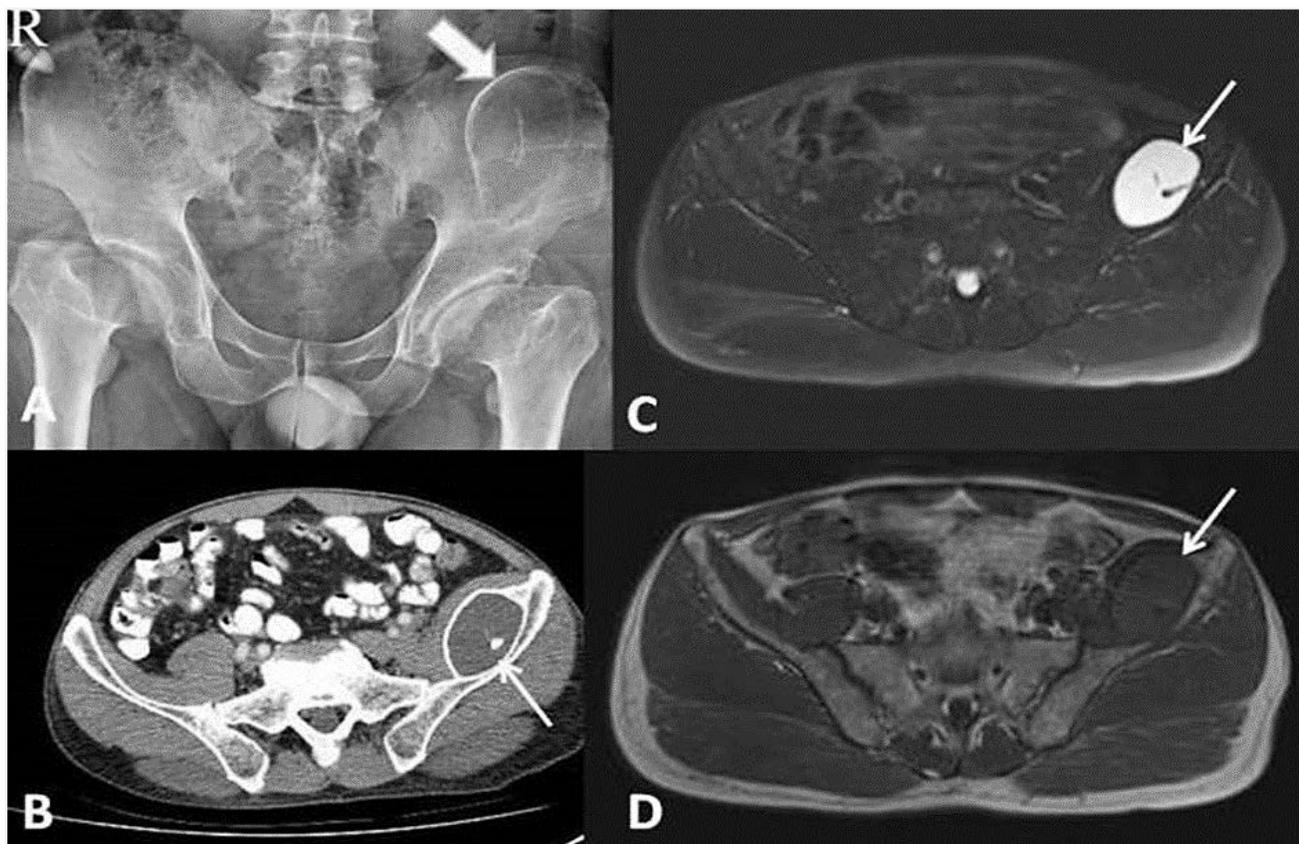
(A) Antero-posterior pelvis radiograph showing large ovoid-shaped ossification on the left iliac bone (thick arrow). (B) Pelvis CT demonstrating an ovoid-shaped lesion (thin arrow) with an ossified periphery and a hypodense center at the level of the left iliac fossa, posterior to the iliac muscle. Pelvis MRI showing a subperiosteal lesion of heterogeneous high signal on fat-suppressed T₂-weighted sequence (C, thin arrow) and iso-/hypointense signal on T₁-weighted sequence (D, thin arrow).
